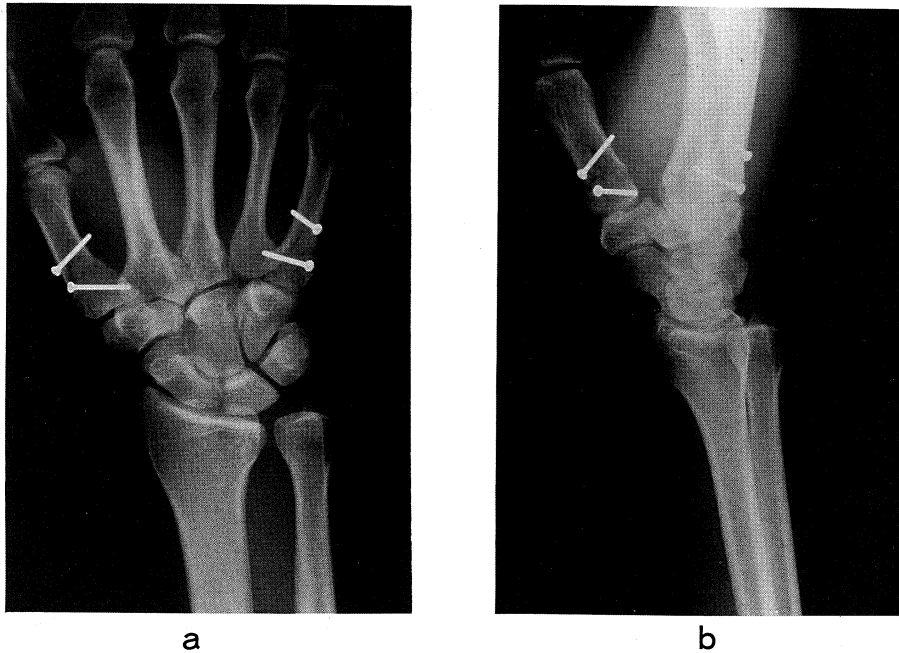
Radiographs taken immediately after operation
